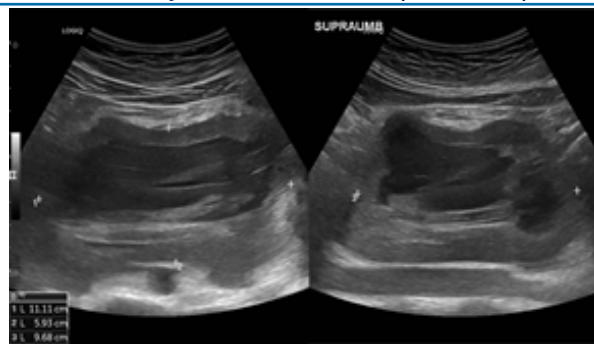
Ultrasound image of the retroperitoneal lesion extending up to the supraumbilical region confirming the central areas of necrosis.
